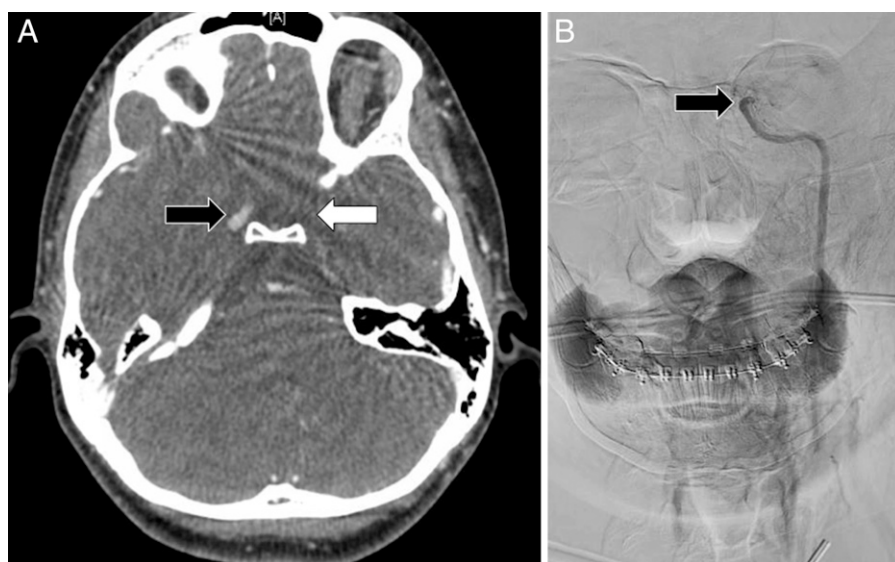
Imaging at the time of presentation. A. Computed tomographic angiogram showing nonopacification of the supraclinoid internal carotid artery (ICA) on the left (white arrow). Normal flow is seen on the right at the same level (black arrow). B. Digital subtraction angiogram. Injection of the left carotid artery shows delayed and diminutive flow throughout a narrowed left ICA, with abrupt tapering at the level of the ophthalmic artery (black arrow). No flow is seen in the middle cerebral artery or its branches.
